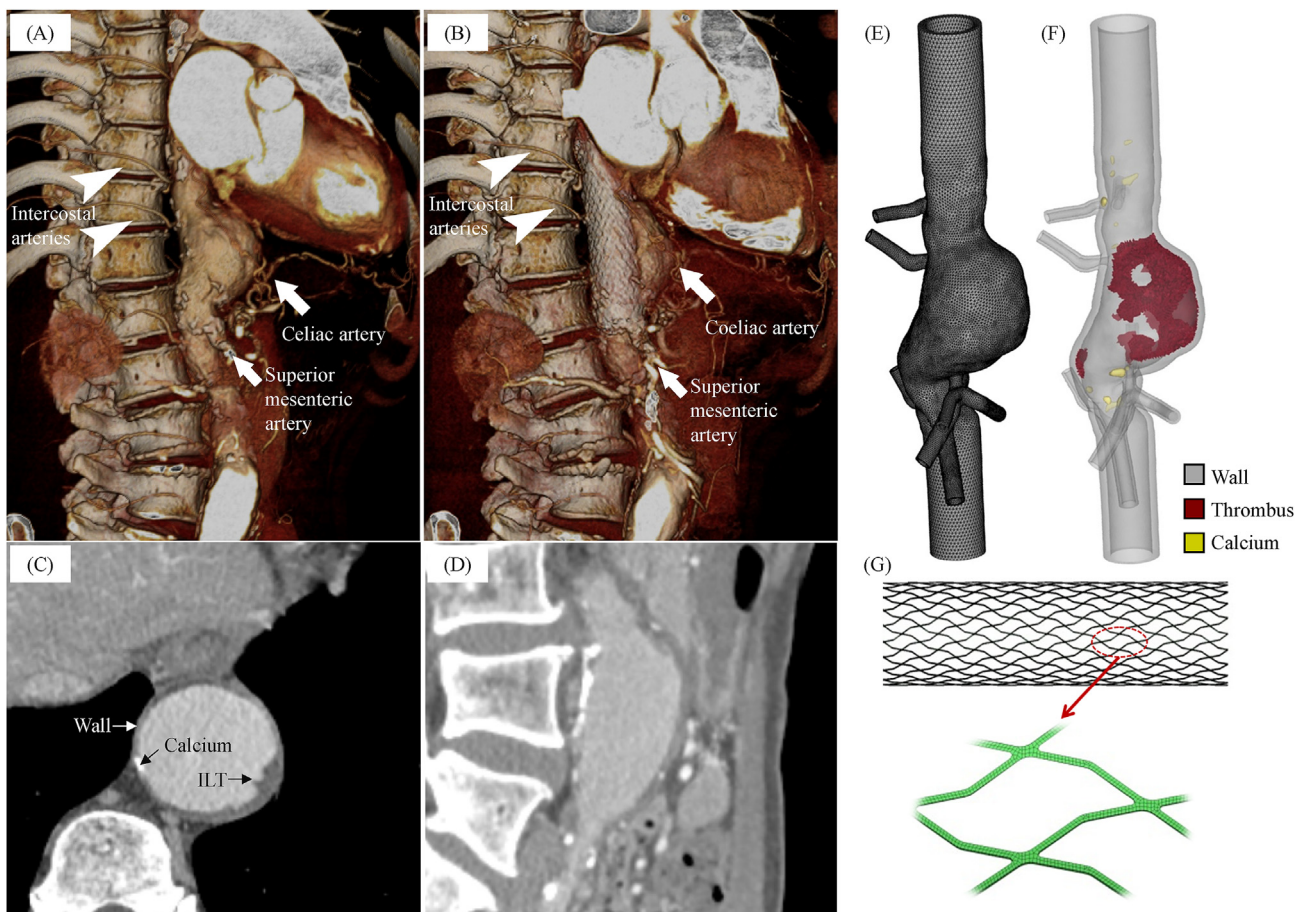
The configuration of a complex aortic aneurysm with vital branches involvement. (A) 3D rendering of the lesion configuration before stent deployment; (B) 3D rendering of the configuration after 4-layer stents deployment; (C) A 2D axial CTA slice; (D) A 2D sagittal CTA slice; (E) Reconstructed 3D geometry with mesh; (F) Sagittal cut showing intraluminal thrombus and calcium; (G) 3D stent model with mesh.
